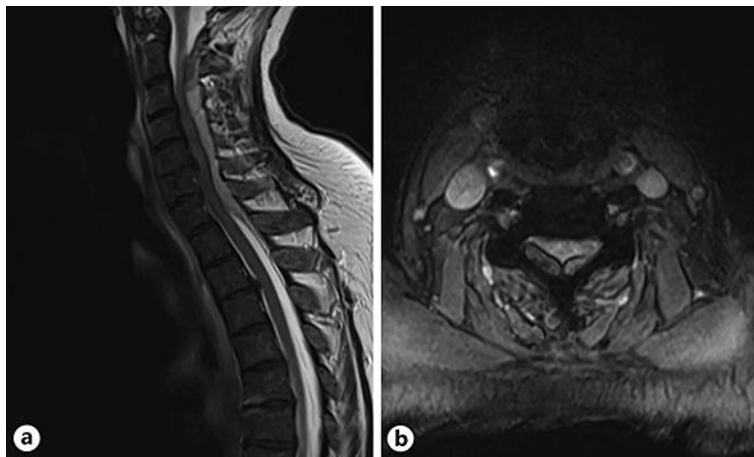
MRI cervical spine T2 sagittal (a) and axial (b) views demonstrating a large epidural haematoma extending from the C2 to the T1 region with evidence of cord compression.
